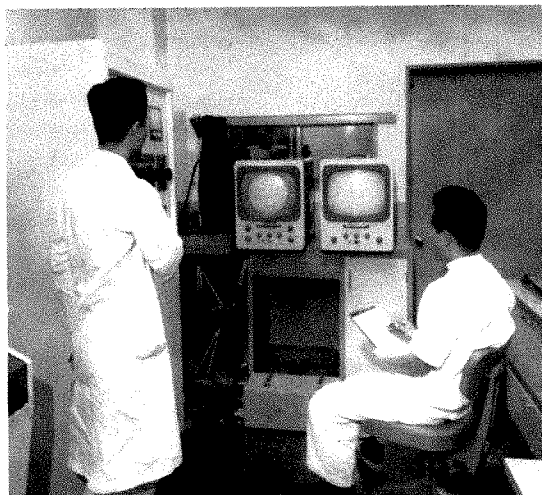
The control room of the x-ray television system. There are two television monitors; the left one is for telefluoroscopy, teleroentgenography and telecineroentgenography and the right one for a general view of the examination room.
